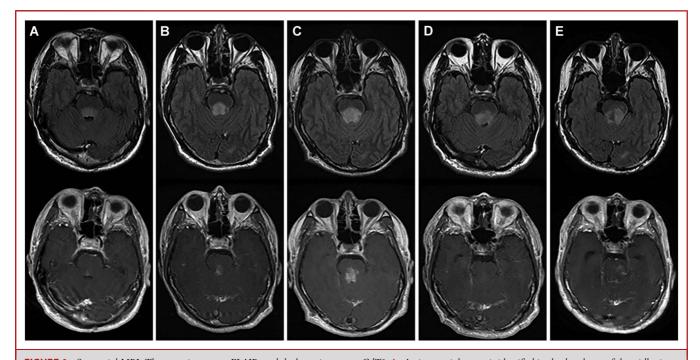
Sequential MRI. The upper images are FLAIR, and the lower images are GdT1. A, An intra-axial tumor is identified in the dorsal part of the midbrain on FLAIR imaging. The tumor shows a small enhancement on gadolinium-enhanced T1-weighted imaging. B, During the follow-up period of 2 months, the tumor enlarges and shows increasing enhancement. C, At 3 months postoperatively, the tumor enlarges and shows increasing enhancement. D, After 2 months of selumetinib use, the tumor shrinks and shows the disappearance of enhancement. E, Six months after discontinuing selumetinib, the tumor exhibited re-enlargement accompanied by increased enhancement. FLAIR, fluid-attenuated inversion recovery.
